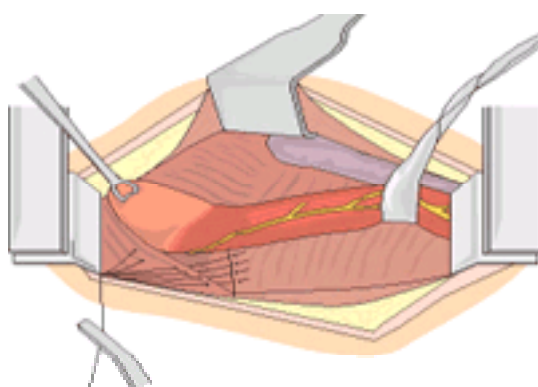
Transthoracic Nissen fundoplication. (2) The vascular fat pad has been excised, and the esophagus is retracted anteriorly for posterior placement of sutures for closure of the hiatus.
